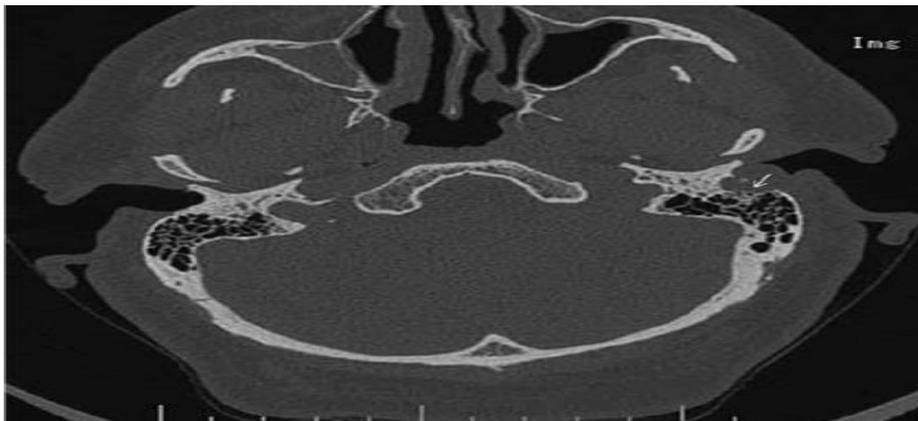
Axial CT image of the tumor on the left external auditory canal
